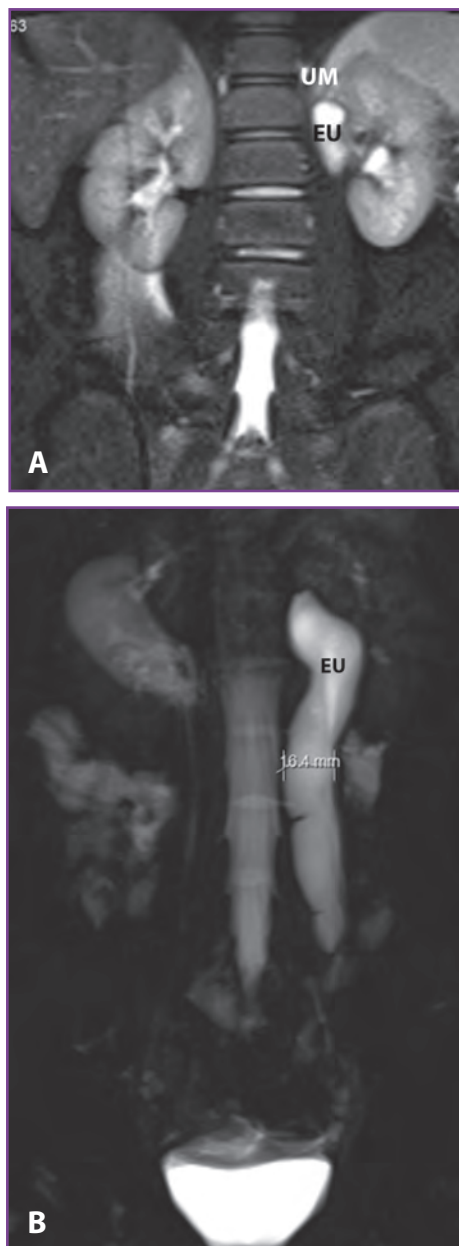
A, Coronal contrast-enhanced magnetic resonance images of a child with dribbling incontinence whose left ectopic ureter (EU) and cryptic dysplastic upper moiety (UM) were not evident at ultrasonography and technetium 99m dimercaptosuccinic acid scanning. B, A 16.4-mm dilated left upper pole ectopic ureter is apparent.
